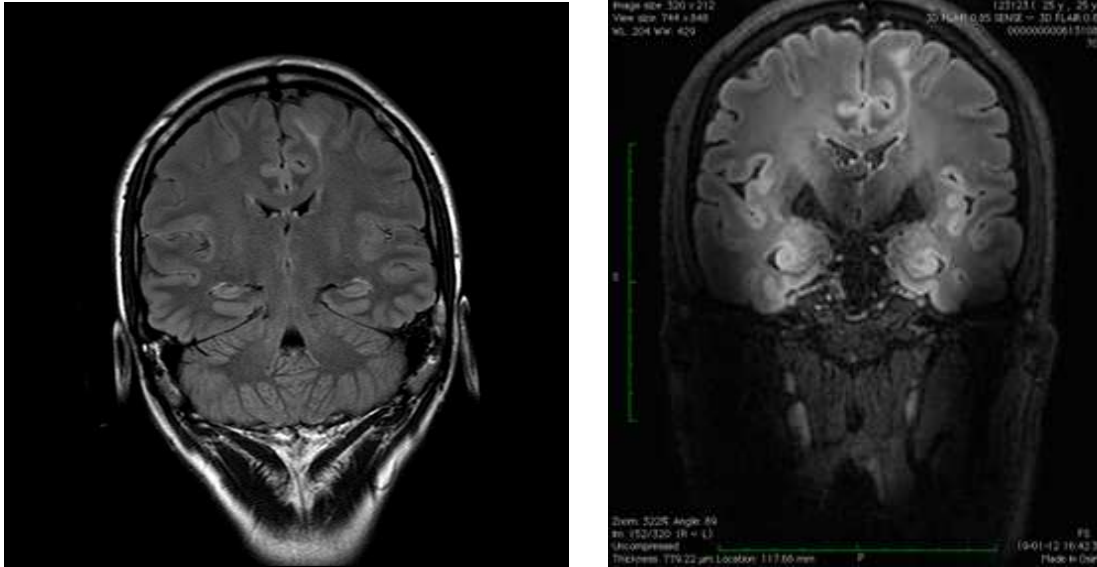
changed diagnoses from original (FCD) to ganglioma. left: 3T MRI. right: 7T MRI.
